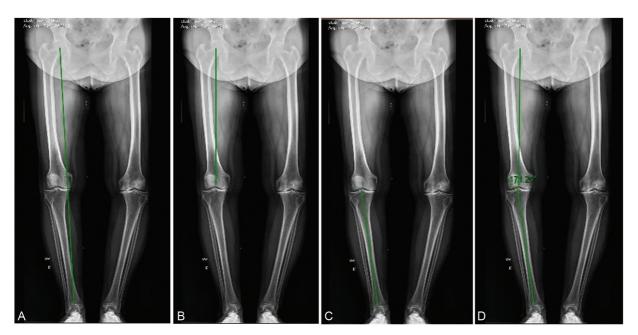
Panoramic radiographs presenting: (A) mechanical axis of the limb; (B) mechanical axis of the femur; (C) mechanical axis of the tibia; (D) femorotibial angle-FTA.
